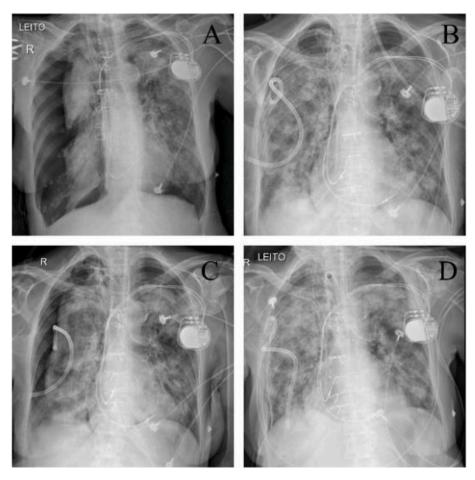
Chest X-Rays of an 88-year-old woman with COVID-19
